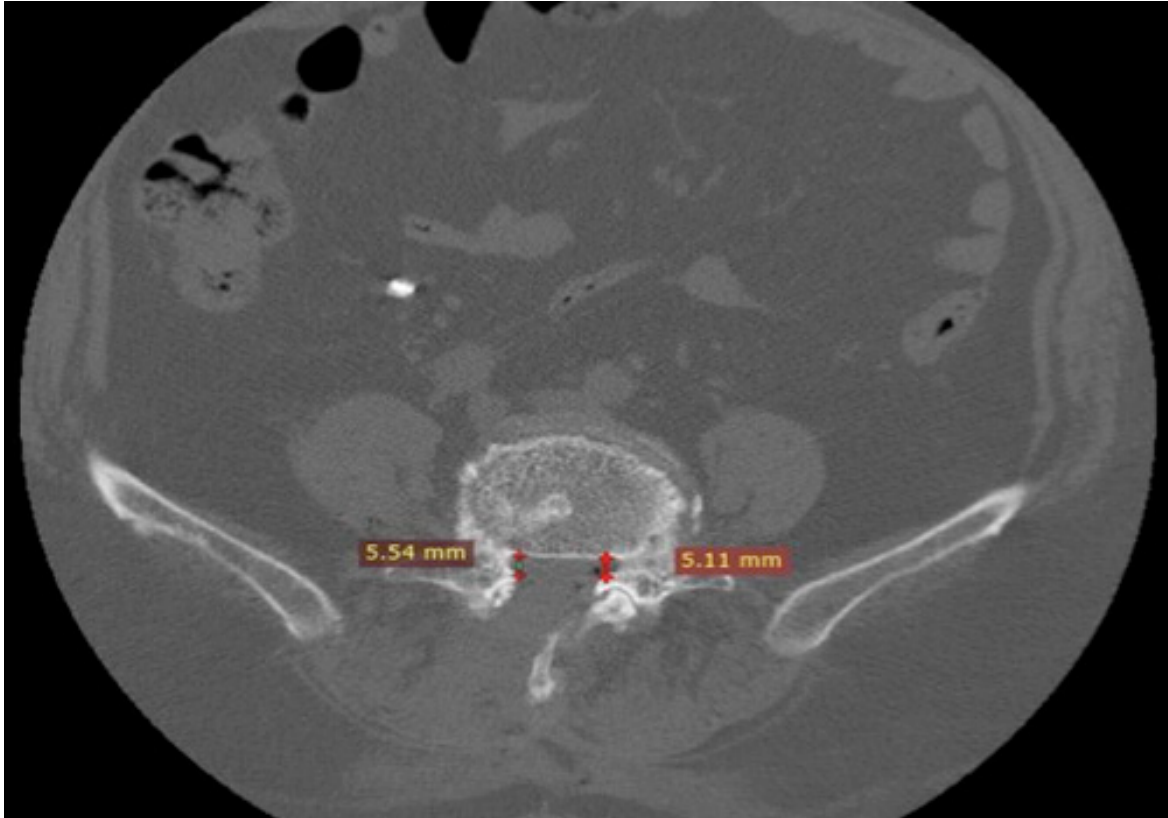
Lateral recess height on postoperative CT scan.
